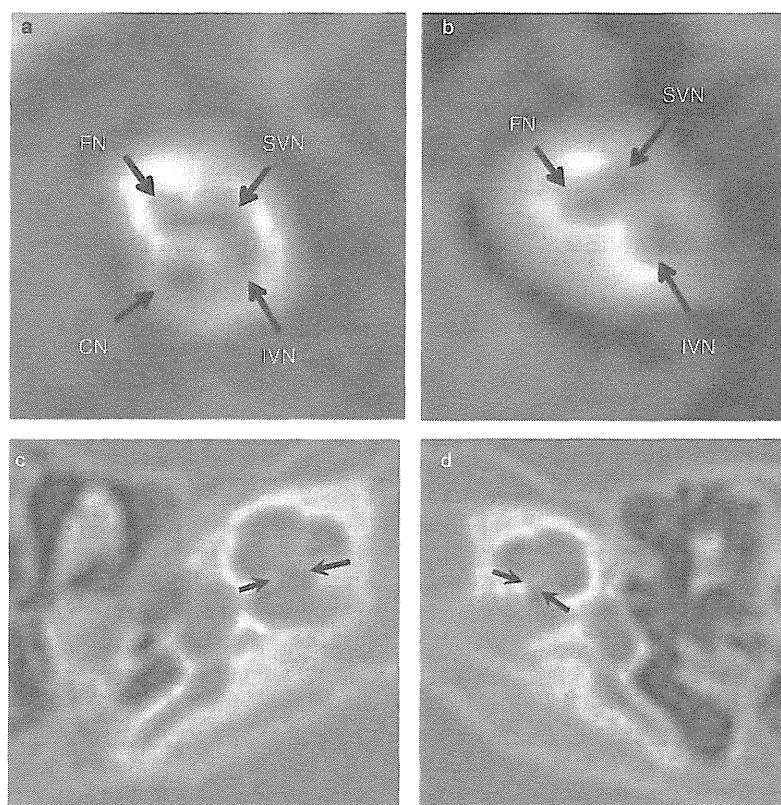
Cochlear nerve hypoplasia in a 5-year-old girl with left sensorineural hearing loss (SNHL) (case 2). (a, b) Oblique sagittal magnetic resonance (MR) images of the inner auditory canal (IAC). Four nerves were detected in the right (a), while the left cochlear nerve is not visible (b). CN, cochlear nerve; FN, facial nerve; IVN, inferior vestibular nerve; SVN, superior vestibular nerve. (c, d) Axial images of temporal bone high-resolution computed tomography (HRCT) show narrowing of left cochlear nerve canal (CNC) (d, 0.7 mm) compared with the right CNC (c, 1.9 mm).
